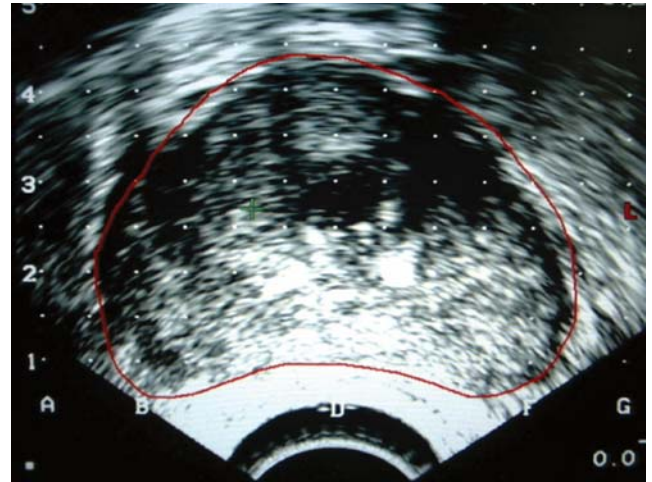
Target volume for brachytherapy planning in ultrasonography transversal section.
